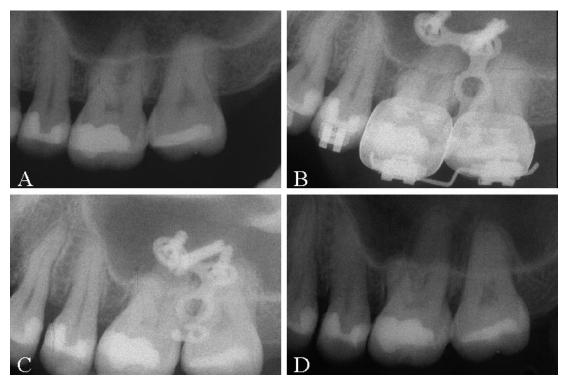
Progressive periapical radiographs. (A) Pretreatment. (B, C) During treatment. (D) Posttreatment after mini-implant removal. Note the amount of root position relative to sinus floor. This indicates the occurrence of bone remodeling while intrusion was achieved.
